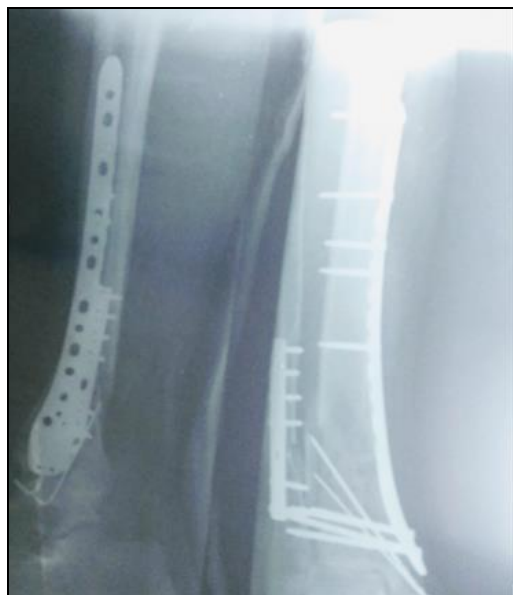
Radiograph at 6 months showing union
